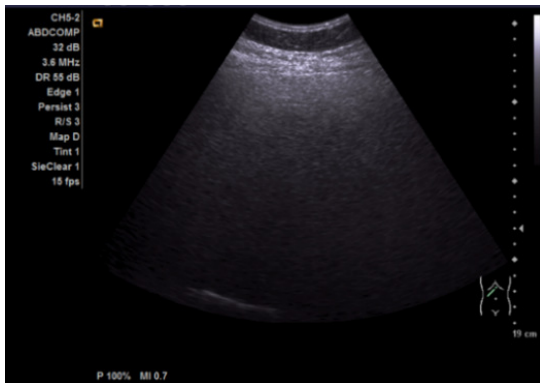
Ultrasonographic bright liver with attenuation
